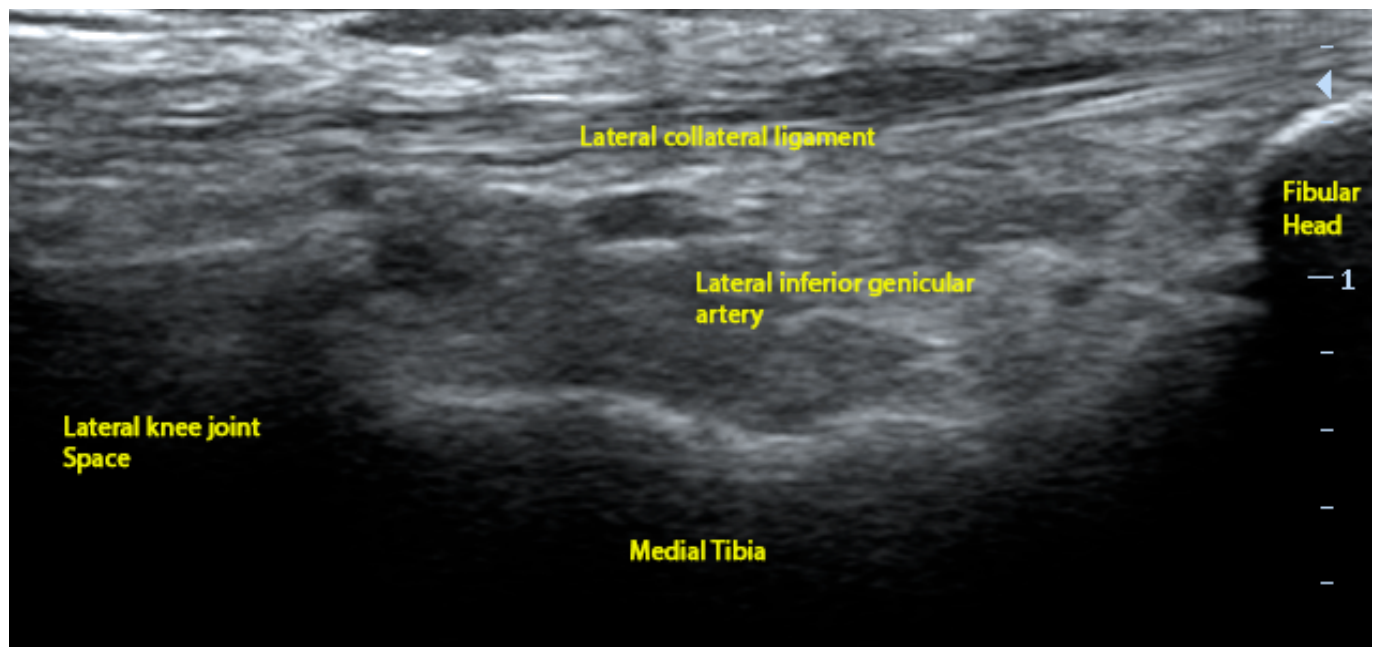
Longitudinal ultrasound image demonstrating the injection site for inferior lateral genicular nerve block.
